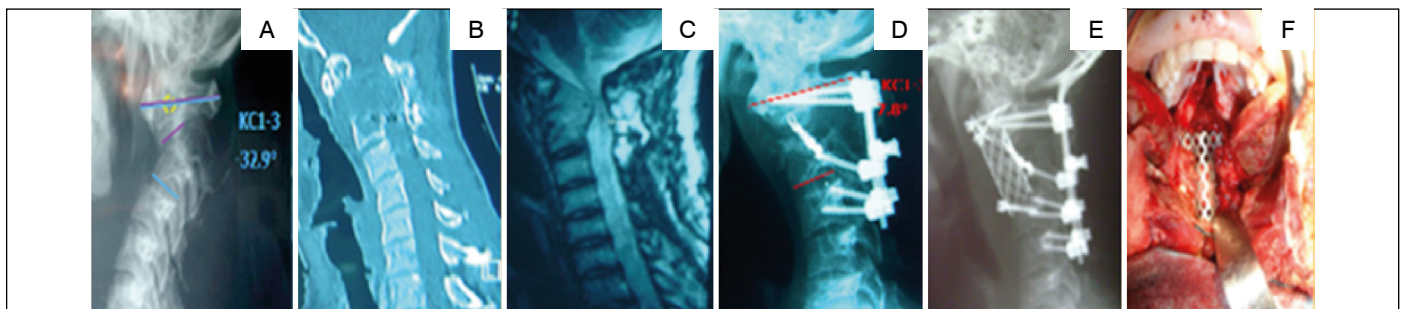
(case 2): A – Cervical Kyphosis. B – Lytic lesion C1-C3. C – T2 sagittal MRI showing tumor and medullary compression. D – C1–C4 posterior fixation. E – Anterior reconstruction C1-C4. F – Intraoperative view.
